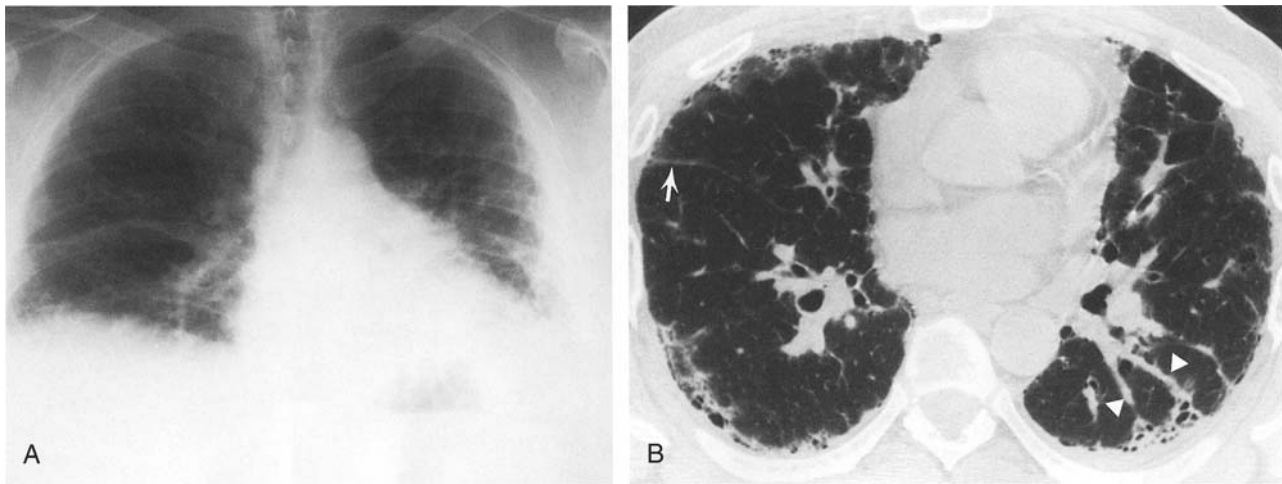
A. A chest radiograph of idiopathic pulmonary fibrosis shows markedly reduced lung volumes and coarse fibrosis concentrated peripherally and at lung bases. B. A high-resolution CT of idiopathic pulmonary fibrosis shows patchy
